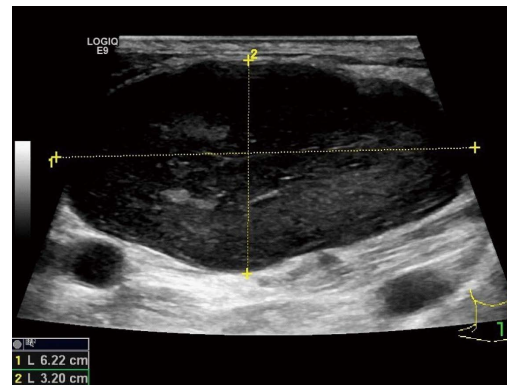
Ultrasonography of cervical mass: The mass was hypoechoic, with a smooth border and un-even internal echo.
